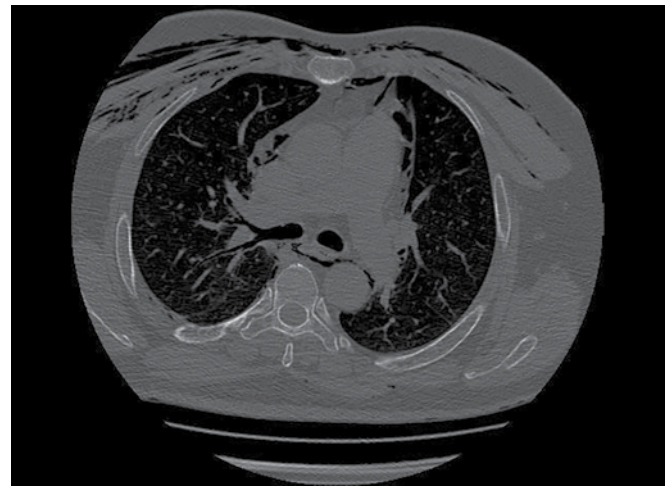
Contrast CT scan axial section showing pneumomediastinum with air around the arteries
